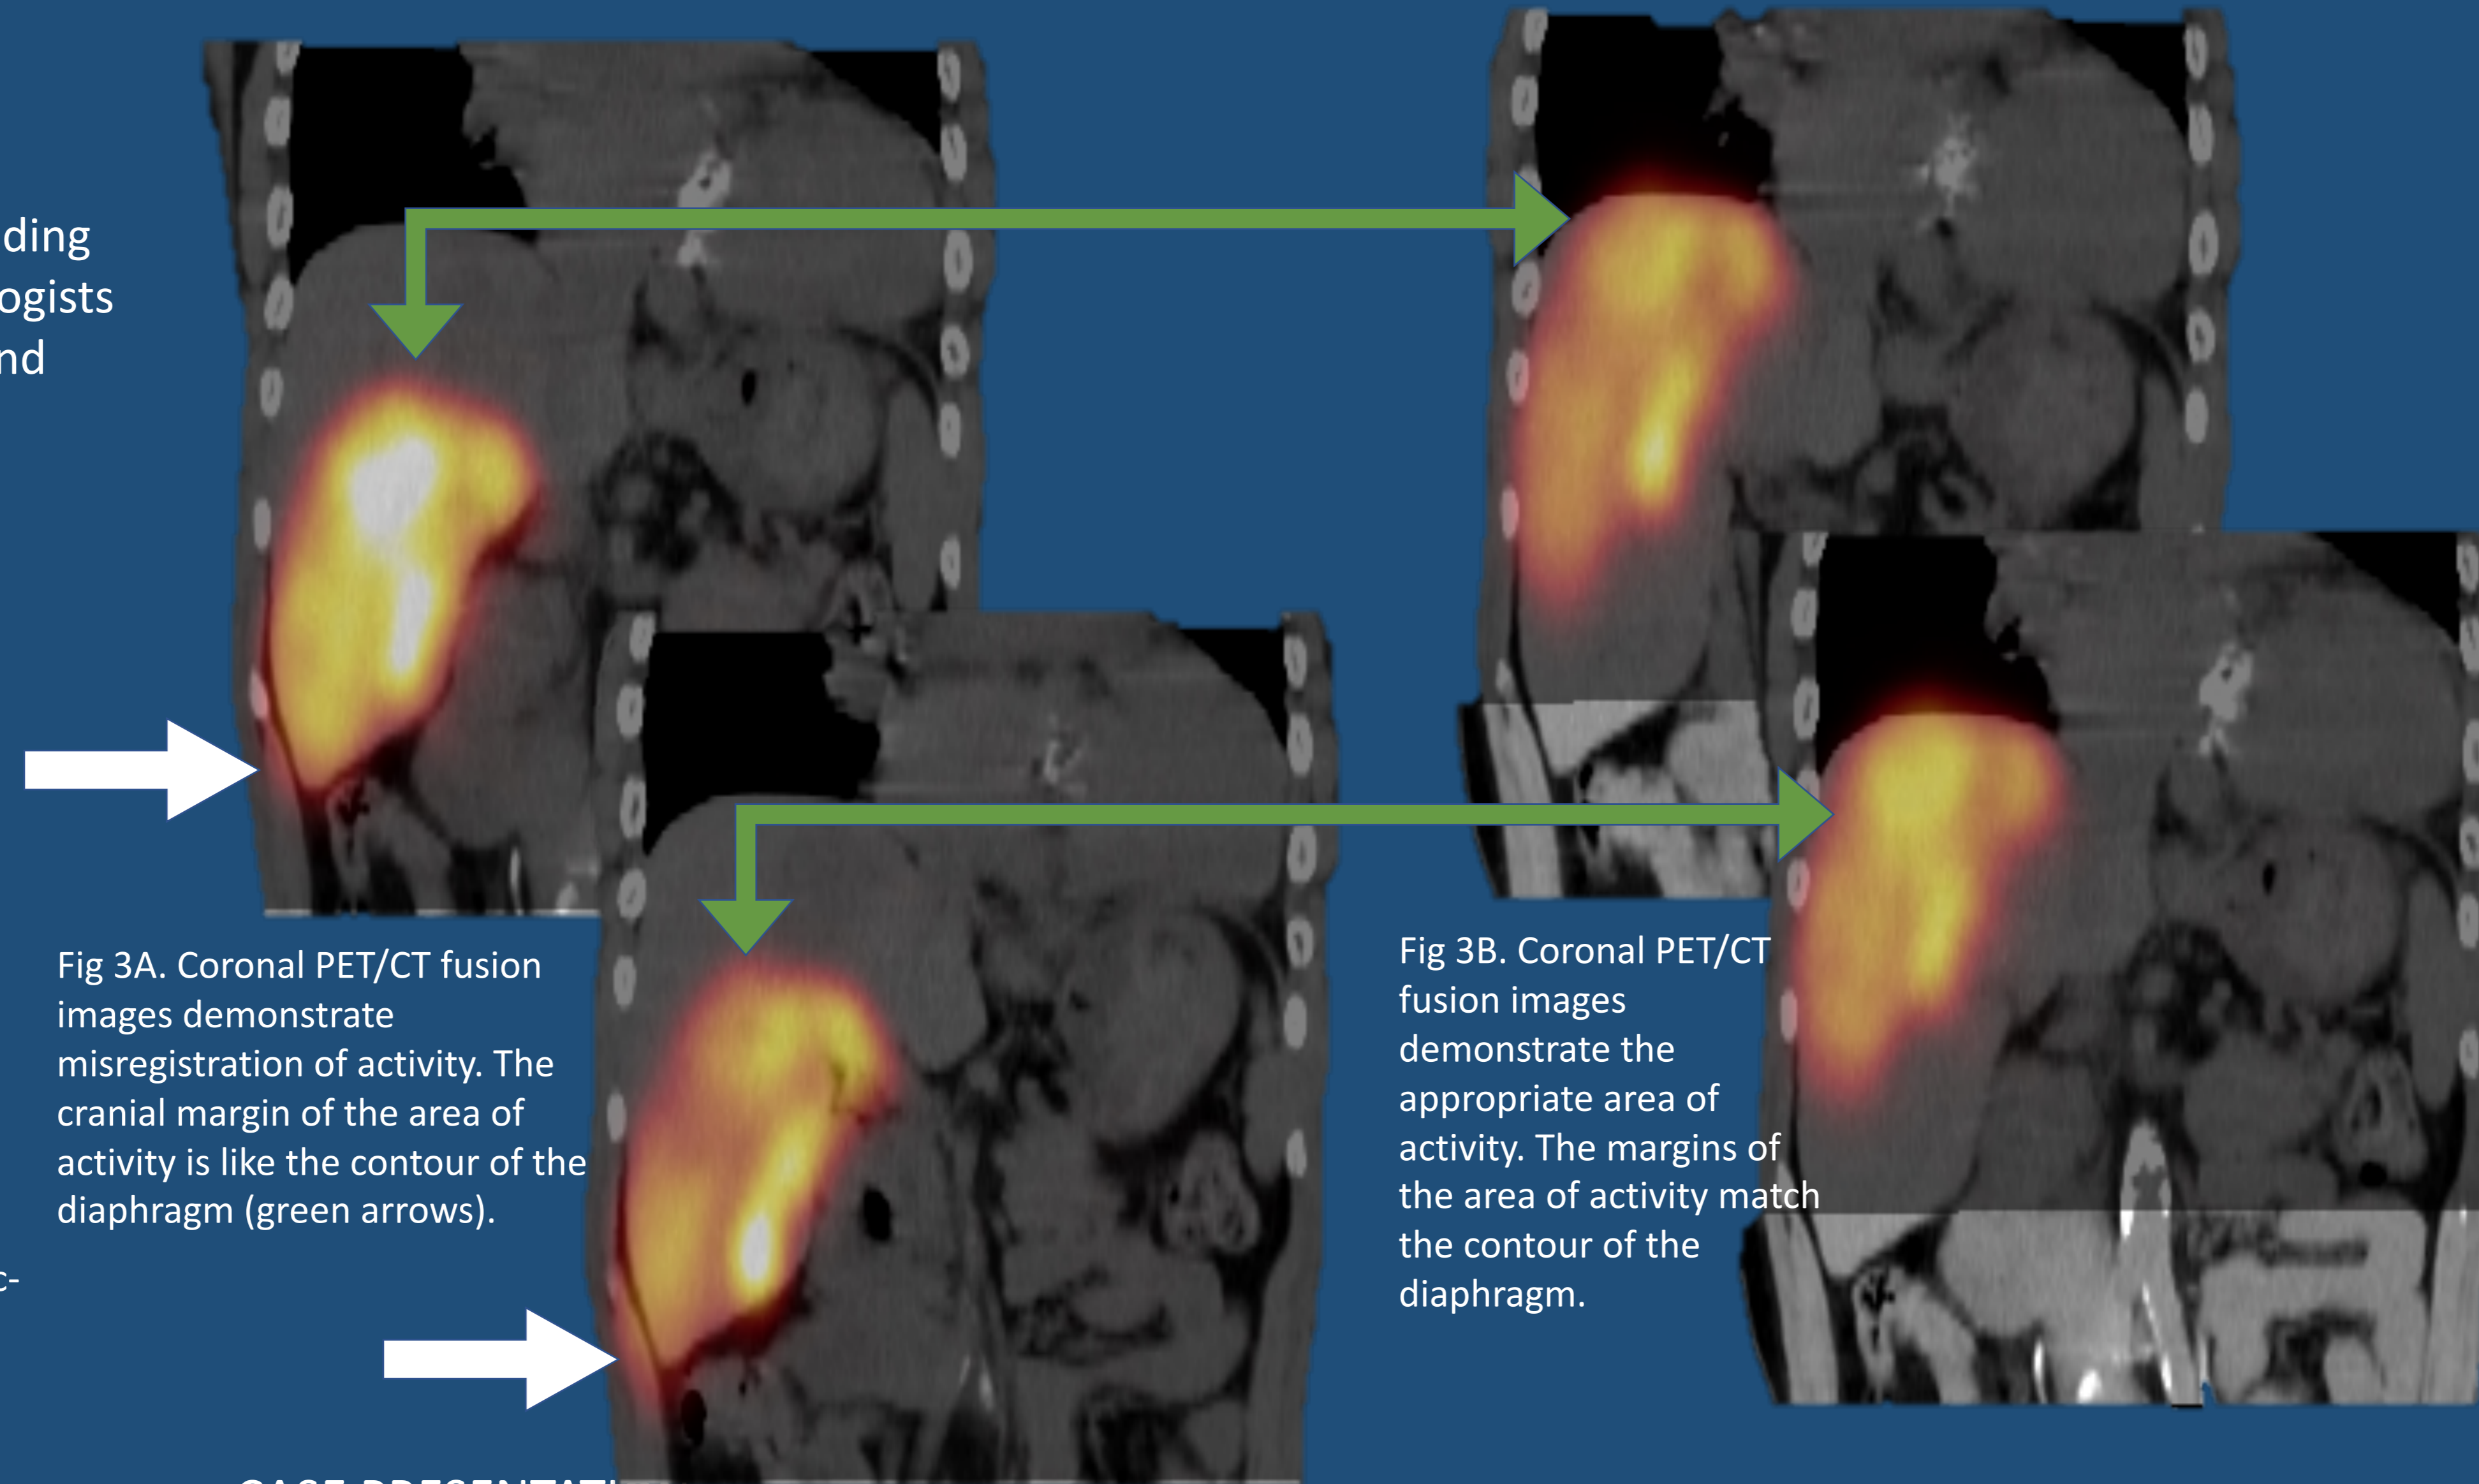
Coronal PET/CT fusion images demonstrate misregistration of activity. The cranial margin of the area of activity is like the contour of the diaphragm (green arrows).
